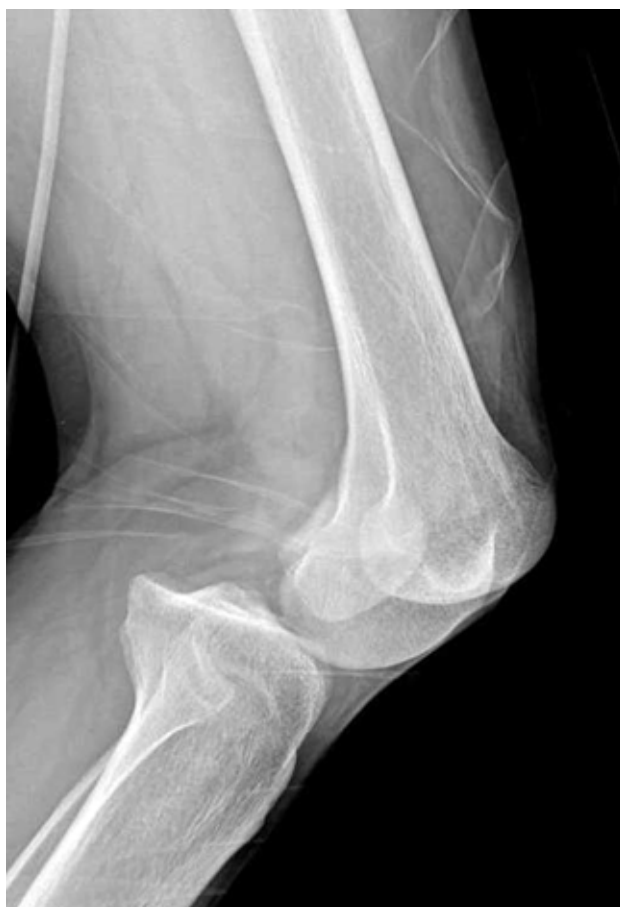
Lateral radiograph of a patient with ACL/PCL/PLC injuries.
